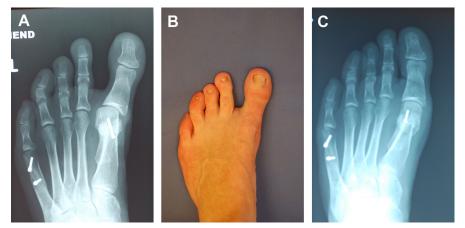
A 46-year-old female with flexible hallux varus deformity and transfer metatarsalgia following SCARF osteotomy is demonstrated. (*A*) Preoperative AP radiograph. (*B*) Preoperative lateral radiograph. (*C*) AP radiograph at follow up after Contra-Chevron osteotomy (performance of Chevron with medialization of the capital fragment), MIS Contra-Akin osteotomy and MIS DMMO of the second and third metatarsal.
